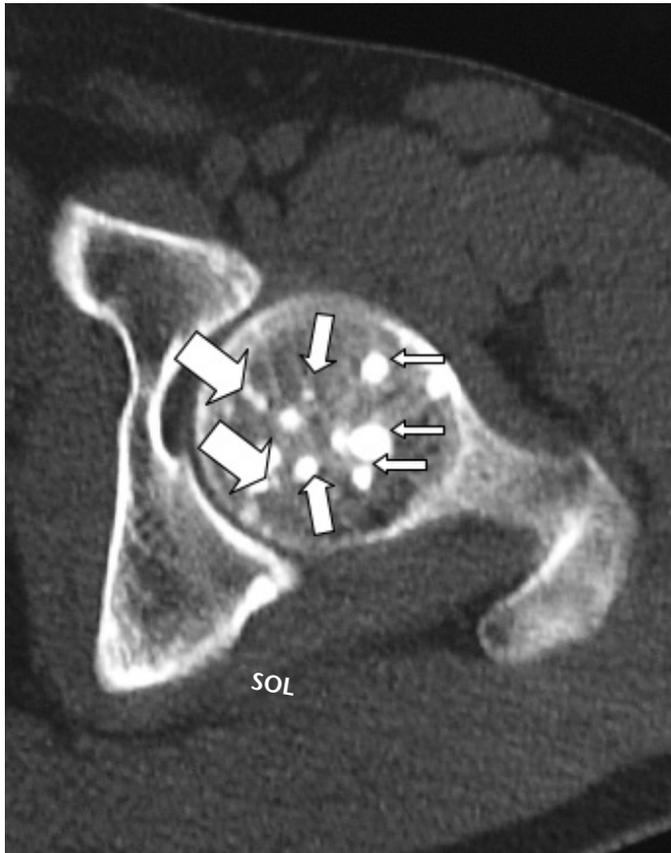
The left hip computed tomography, transverse cross-section passing through the femoral head. White arrows show numerous hyperdense lesions that conform with the osteopoikilosis in the femoral head; lesions are well-circumscribed and have size in millimeters
